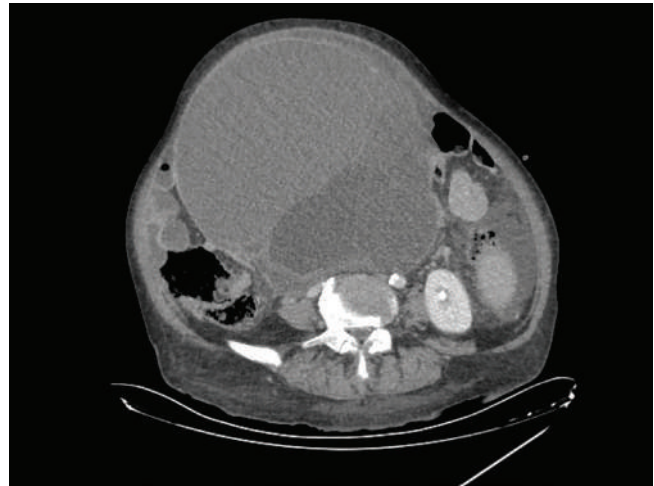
Preoperative CT image. Imaging of intraabdominal giant mass.
